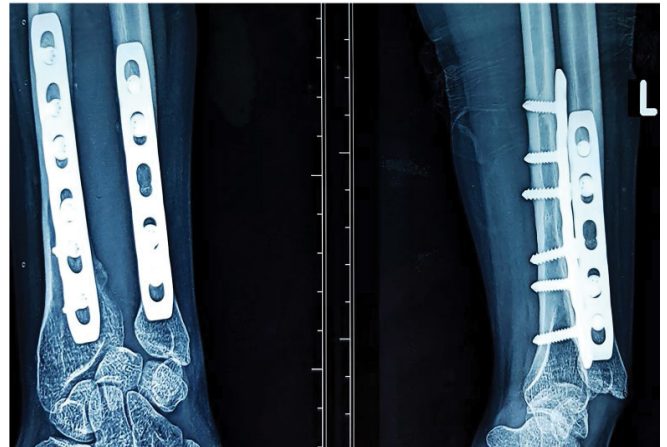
Postoperative radiograph showing the outcomes of corrective radial and ulnar shortening osteotomies. No instability of the distal radioulnar joint articulation can be observed.
